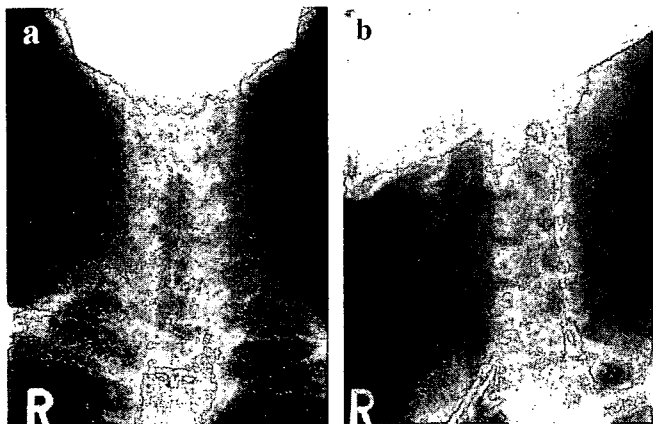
a, b, Preoperative radiography of the cervical spine shows left expanding C3–C4 intervertebral foramen with scalloping and clear sclerotic margins.
